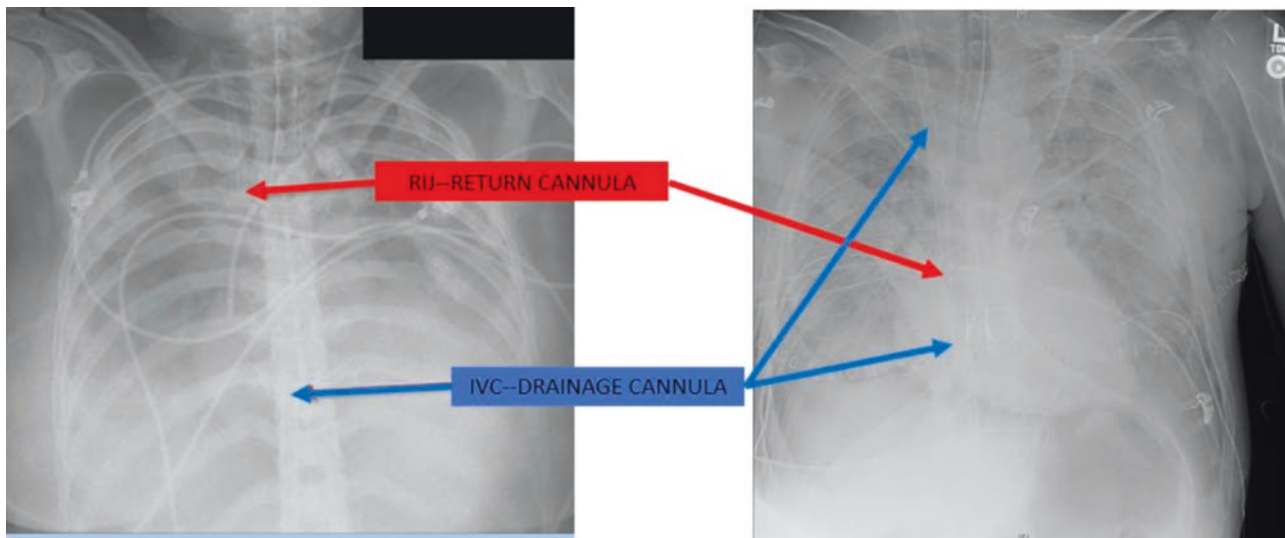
Chest X-ray after venovenous ECMO. (a) Separate cannulas for VV-ECMO: RIJ cannula and IVC cannula. (b) Dual-lumen single cannula for VV-ECMO
